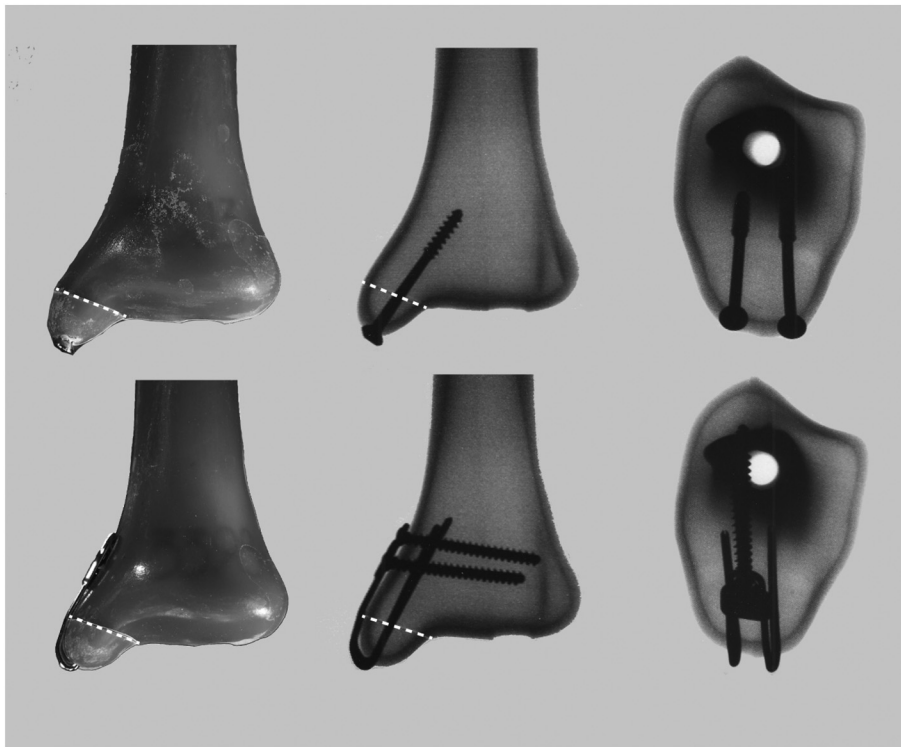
Pre-testing images of the parallel unicortical cancellous screw construct (top left) and medial malleolar sled construct (bottom left). Anterior-to-posterior X-rays of the parallel unicortical cancellous screw construct (top middle) and medial malleolar sled construct (bottom middle). Axial X-rays of the parallel unicortical cancellous screw construct (top right) and medial malleolar sled construct (bottom right). Dashed lines indicate osteotomy cuts.
